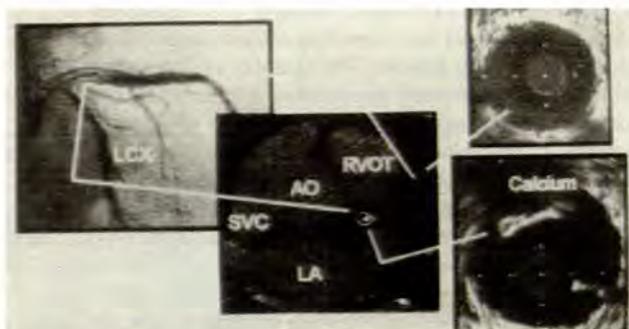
Comparison of coronary angiography, intravascular sonography and EBCT-determined calcium deposition. Shown are two segments of a coronary artery laden with plaque. One segment (distally) is normal by all three methods. The proximal segment shows a plaque by sonography and EBCT but is normal by angiography. (Reproduced with permission from the American College of Cardiology.²⁹)
